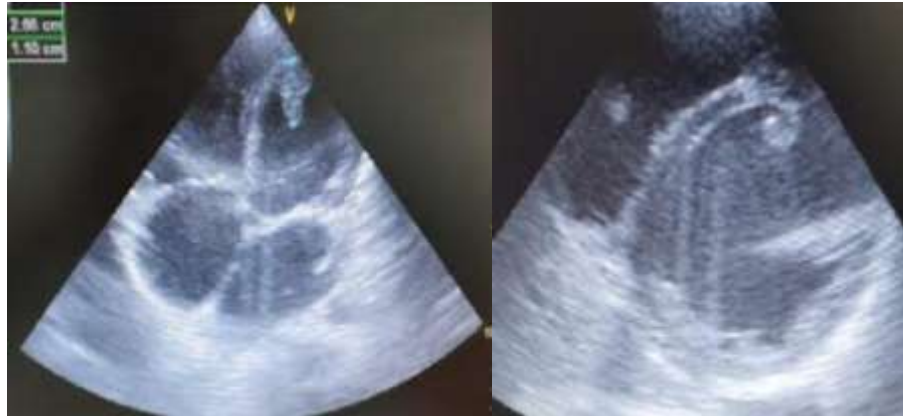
Echocardiographic image showing ventricular thrombi.
